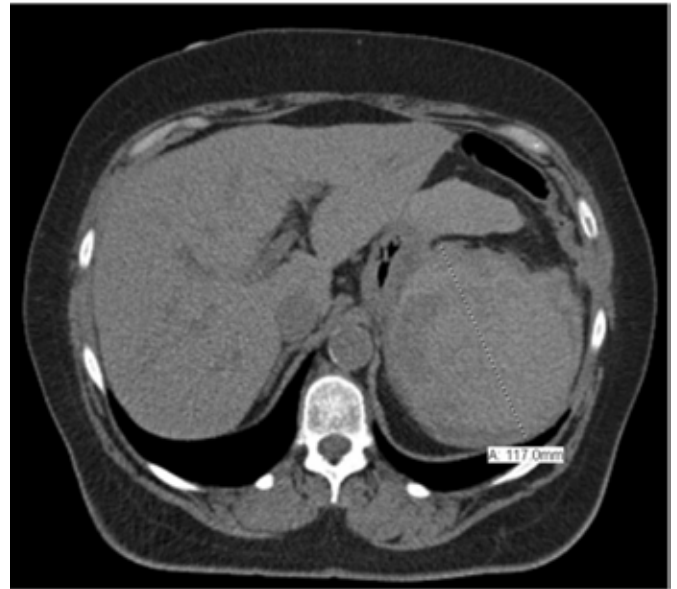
Computed tomography of a 60-year-old woman after colonoscopy with splenic rupture performed without contrast<sup>4</sup>.
